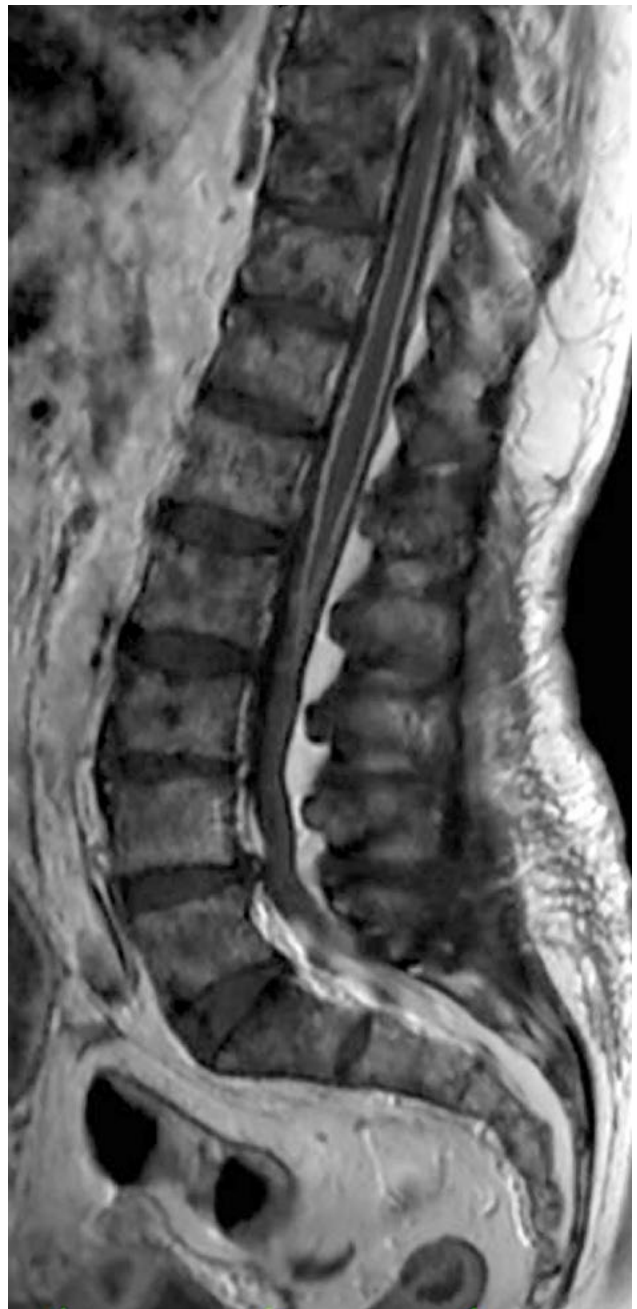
Leptomeningeal perimedullary enhancement on sagittal T1-weighted, gadolinium-enhanced magnetic resonance imaging of the spinal column.
